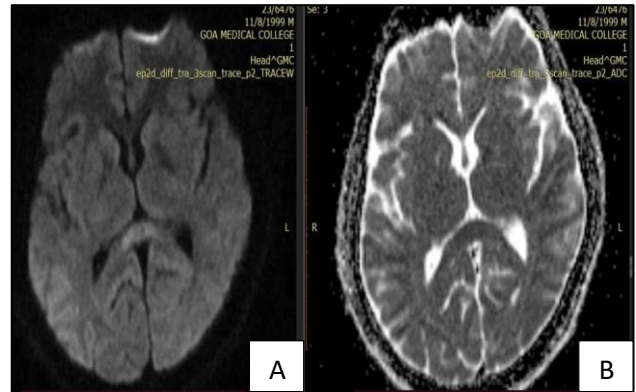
(A and B): DWI & ADC sequences of the same patient showing hyperintense signal with corresponding ADC values suggestive of restricted diffusion in the splenium of corpus callosum.
